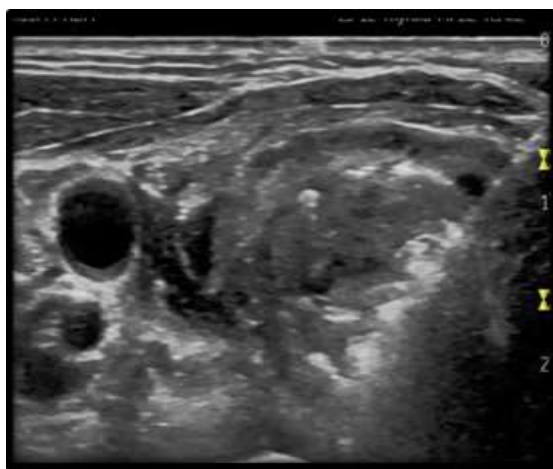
Ultrasonographic findings of the antenna of microwave needle seen at the thyroid nodule with hyperechoic thermal cloud around it.
